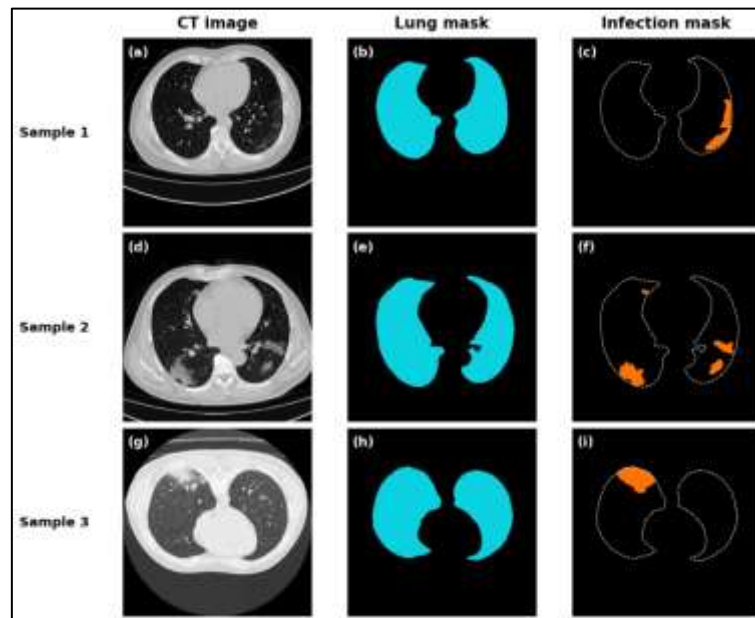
COVID-19 CT dataset overview showing representative axial CT images together with corresponding lung and pulmonary infection annotations used for model development and evaluation.
